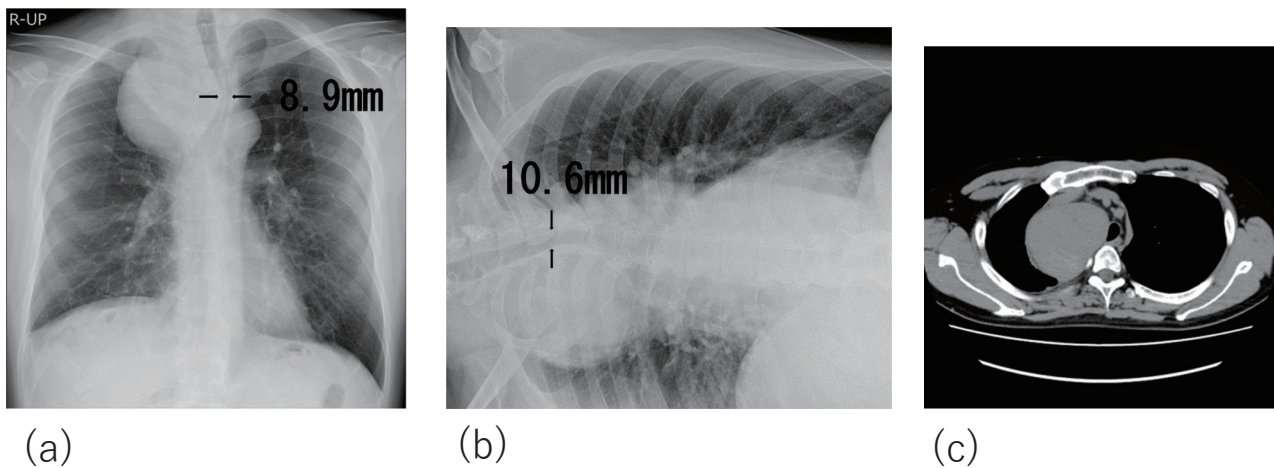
(a) Pre-operative radiograph, standing position. (b) Pre-operative radiograph, right lateral position. (c) Pre-operative radiograph, supine position.
